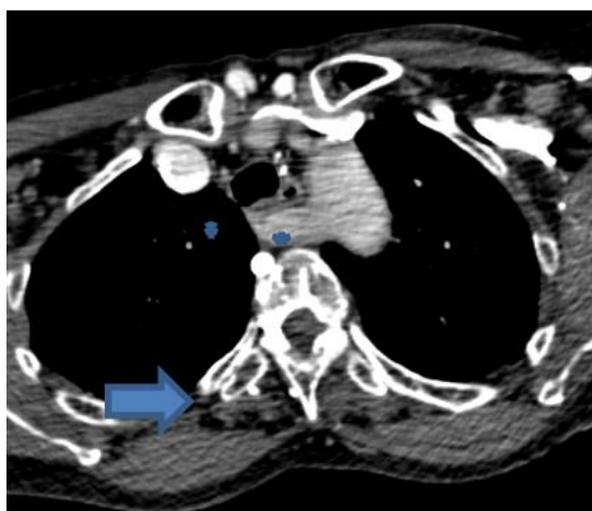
Postcontrast Computed Tomography – Angiography axial image Arteria lusoria (bleu arrow) crosses the midline between the spine and the eosophagus. Both common carotid arteries (bleu stars), originate from a common trunk. There is no abnormality of origin of the left subclavian artery
